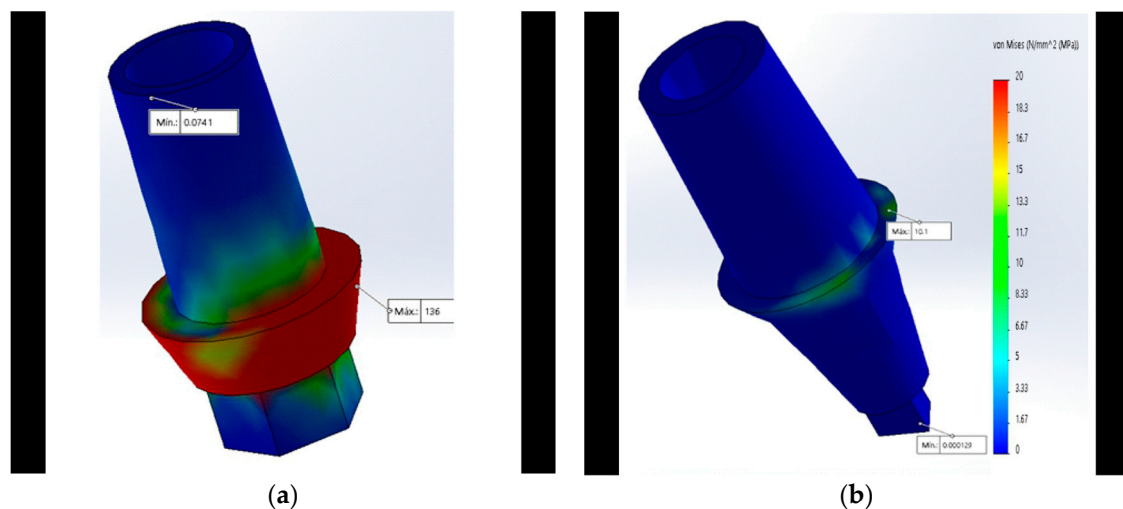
Maximum stress with 350 N at the abutment is represented by the red color using the von Mises scale: (a) Maximum stress at the neck in the IH connection; (b) maximum stress at the neck in the CT was lower (represented by the green color).
